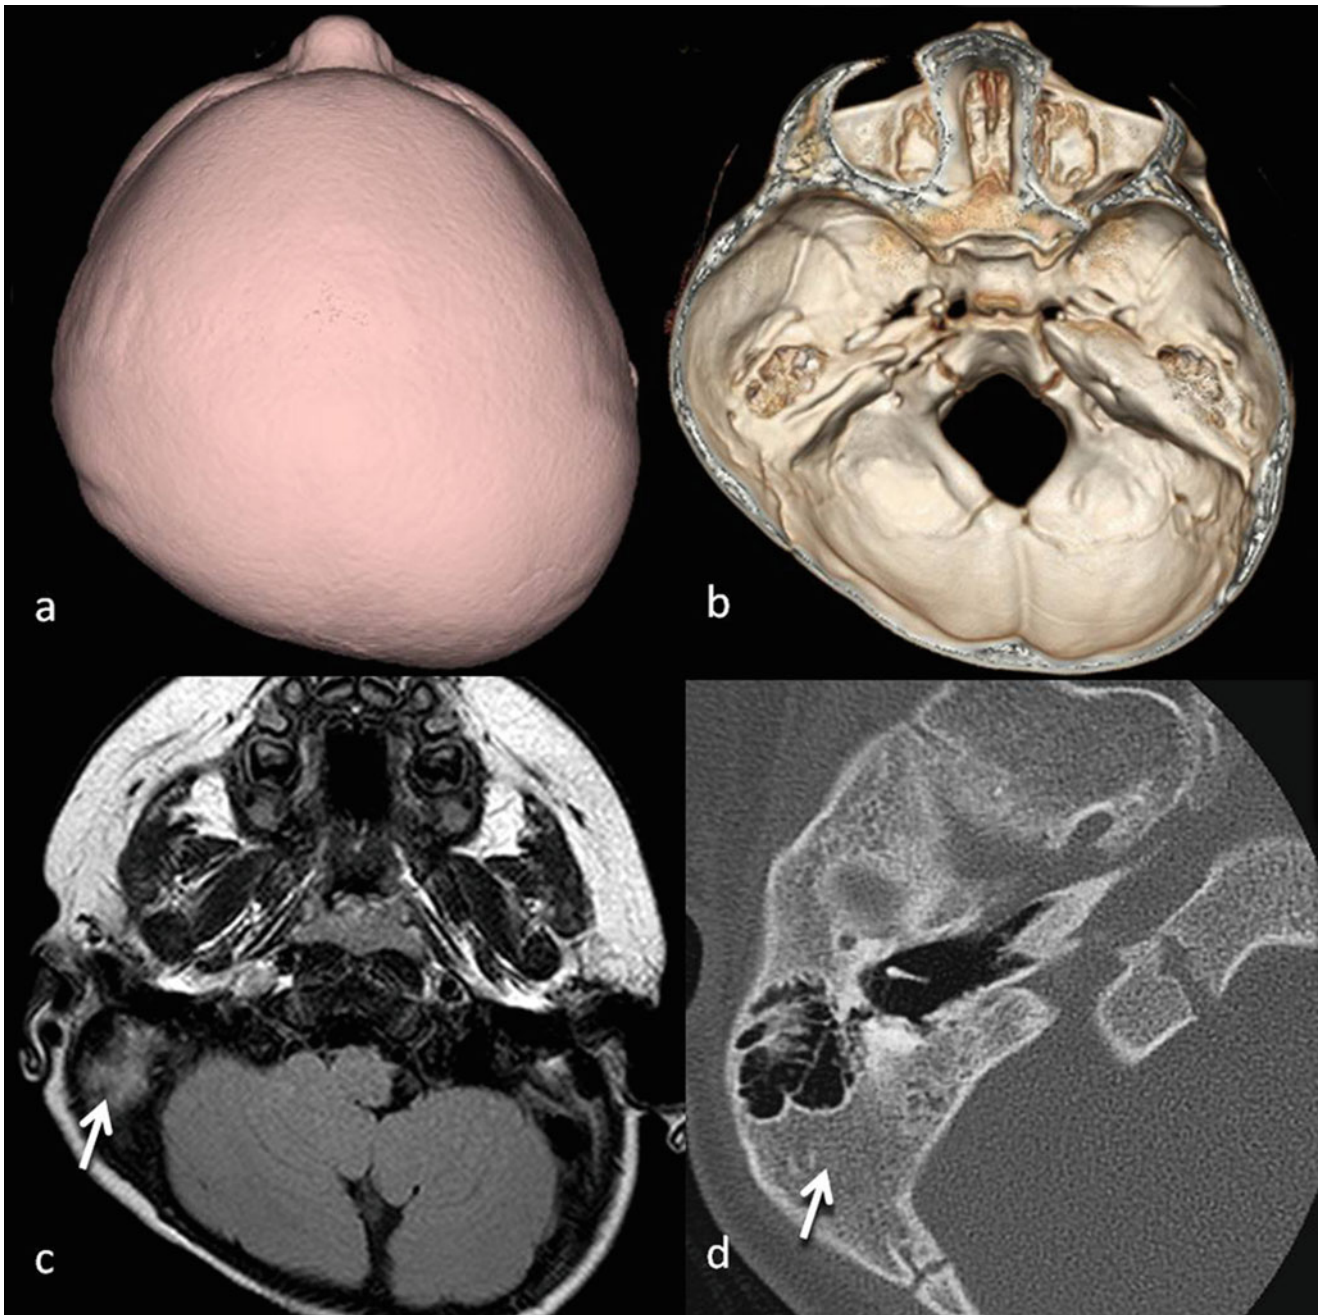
Posterior flattening of the skull and marrow filled mastoid in an infant. (a) CT 3D skin surface and (b) skull base reconstruction shows flattening of the right side of the skull due to prolonged supine
